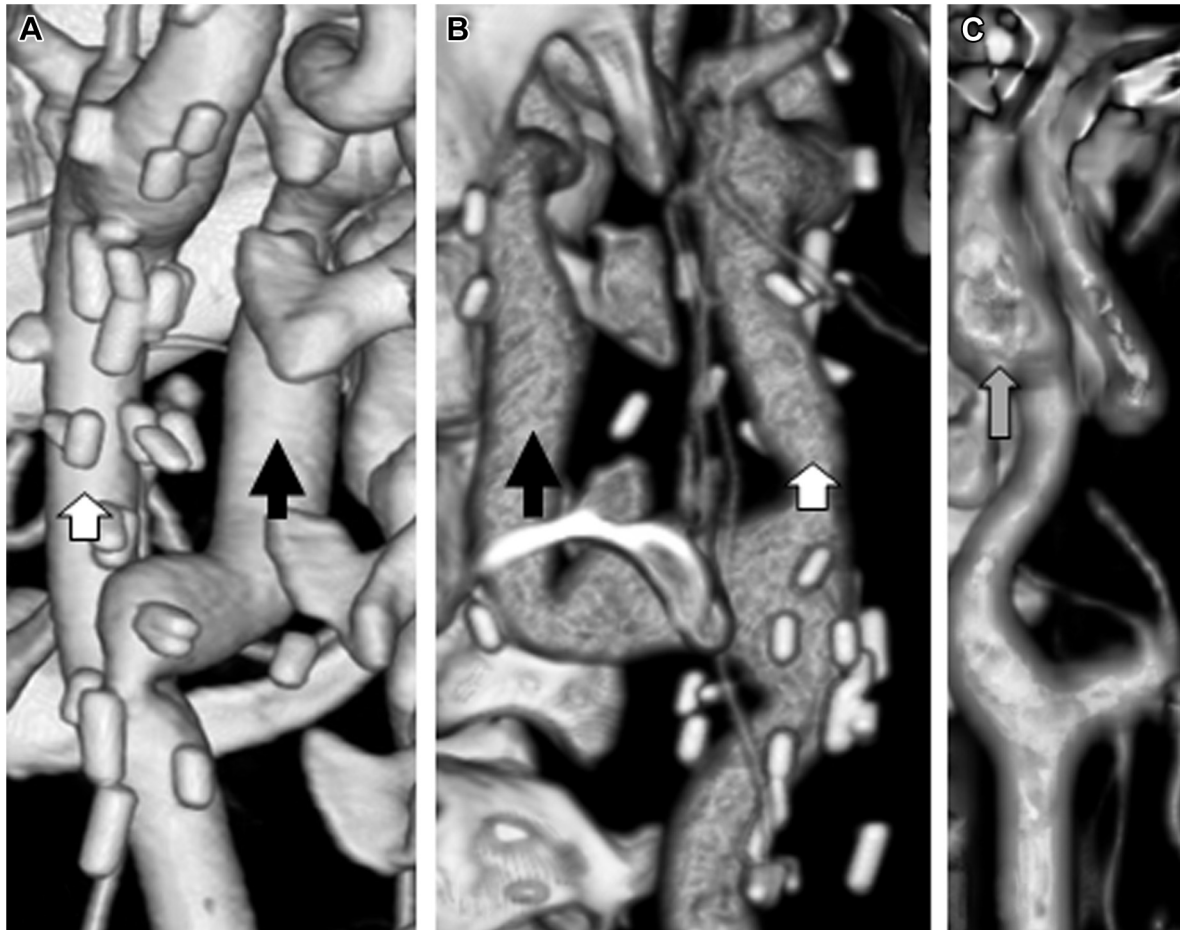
Three-dimensional computed tomography arteriogram (CTA) reconstruction demonstrates (A) proximal anastomotic stenosis and early vein graft dilation at 12 months after the operation, (B) vein graft dilation, and (C) a right internal carotid aneurysm at 30 months. The saphenous vein graft diameter equals or exceeds that of common carotid. The *black arrow* indicates the saphenous vein graft, the *white arrow* indicates the common carotid artery, and the *gray arrow* indicates the right internal carotid aneurysm.
